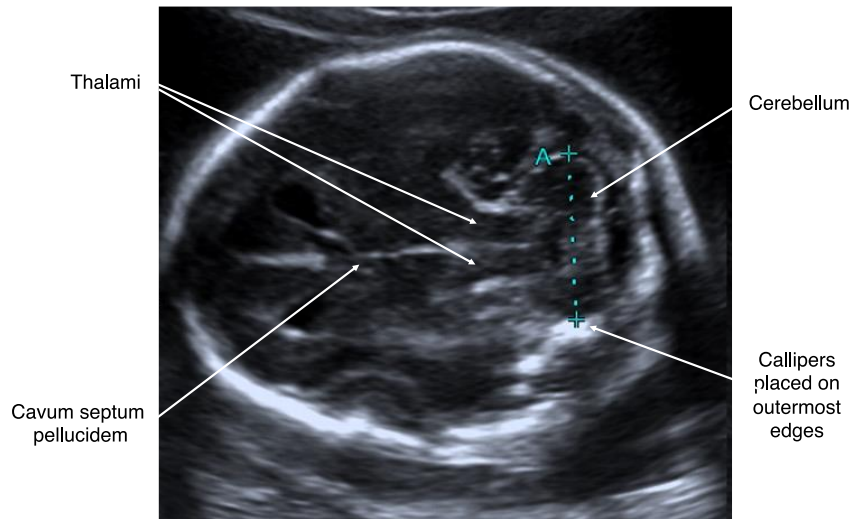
Ultrasound view required for the measurement of transcerebellar diameter (TCD) >14 weeks gestation.
